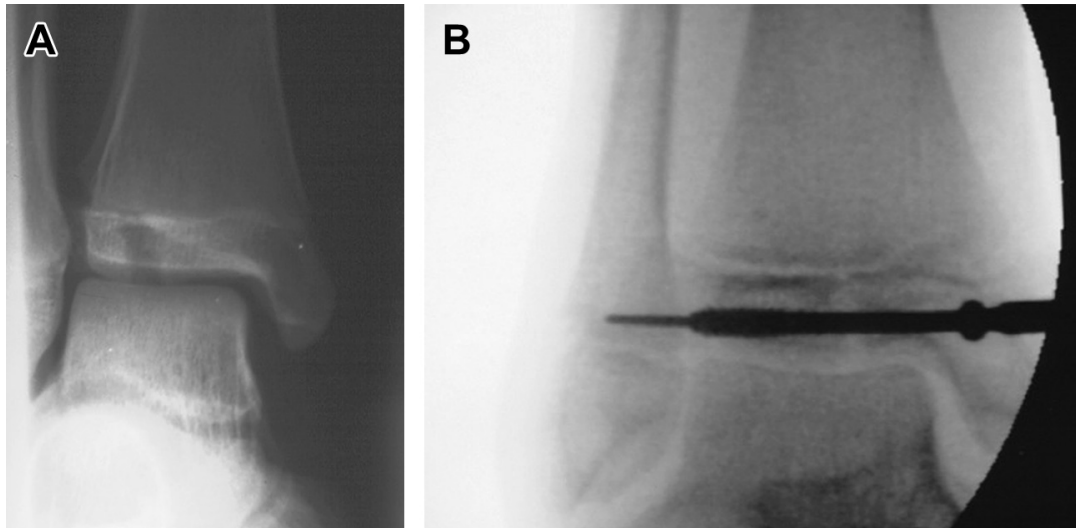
(A) Juvenile Tillaux fracture. This represents a Salter Harris III fracture pattern in the transitional period of development. Because this fracture is intra-articular, careful assessment of displacement should be made with multiple radiographic views and CT scan. (B) Intraepiphyseal reduction technique utilizing cannulated screw. The fixation does not enter or cross the physis, so removal is typically not necessary.
